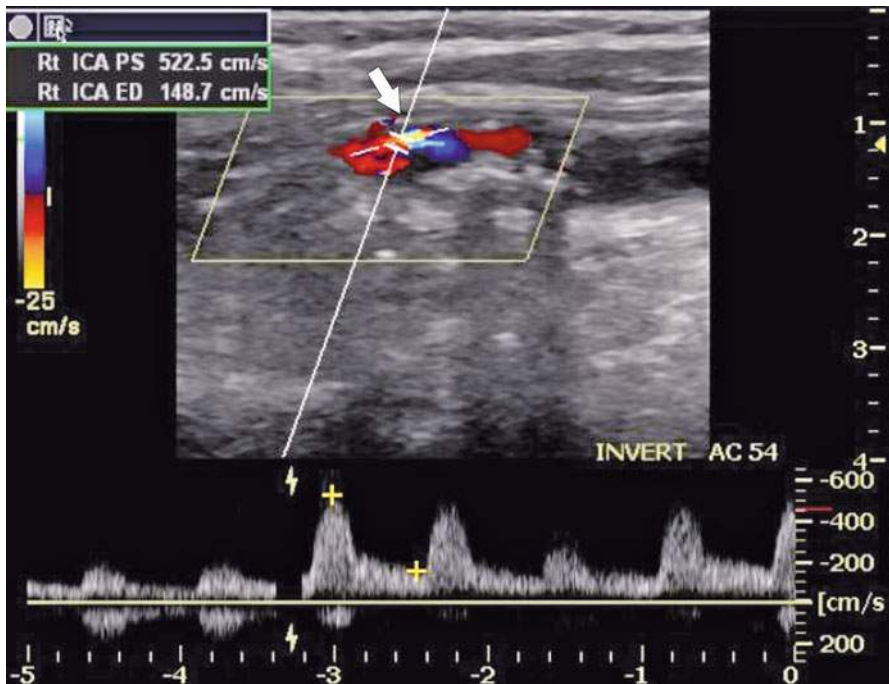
Carotid artery stenosis. Carotid artery US with Doppler shows turbulent flow (*arrow*) with high velocity (*calipers*) indicating narrowing
